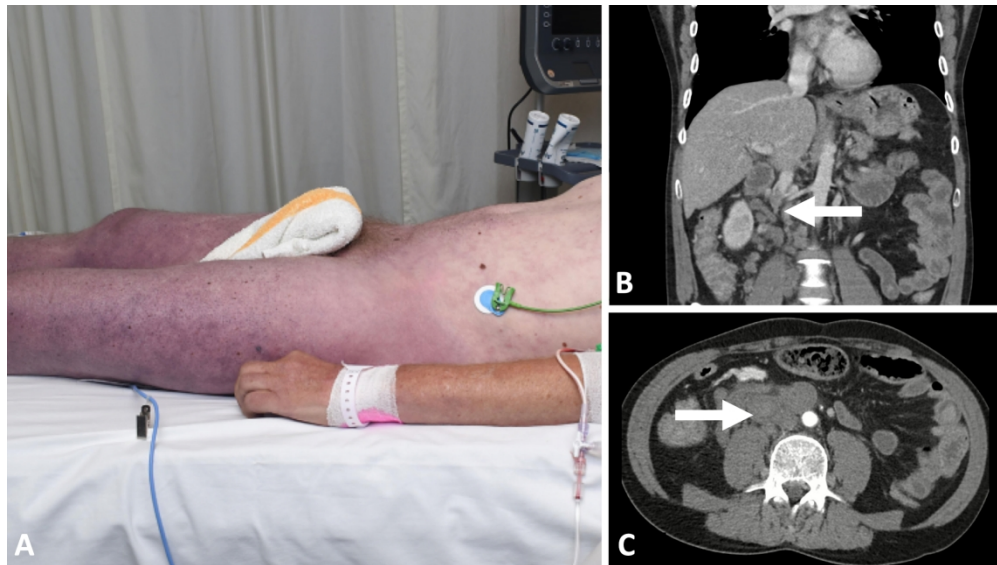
Findings on clinical and computed tomography examination. (A) blueish discoloration of the abdomen and lower extremities with clear evidence of venous congestion, (B, C) arterial contrast-enhanced coronal (B) and axial (C) computed tomography images revealing an inferior caval vein syndrome caused by a compressive collection of lymph nodes (arrows indicate the location of lymph node collection).
